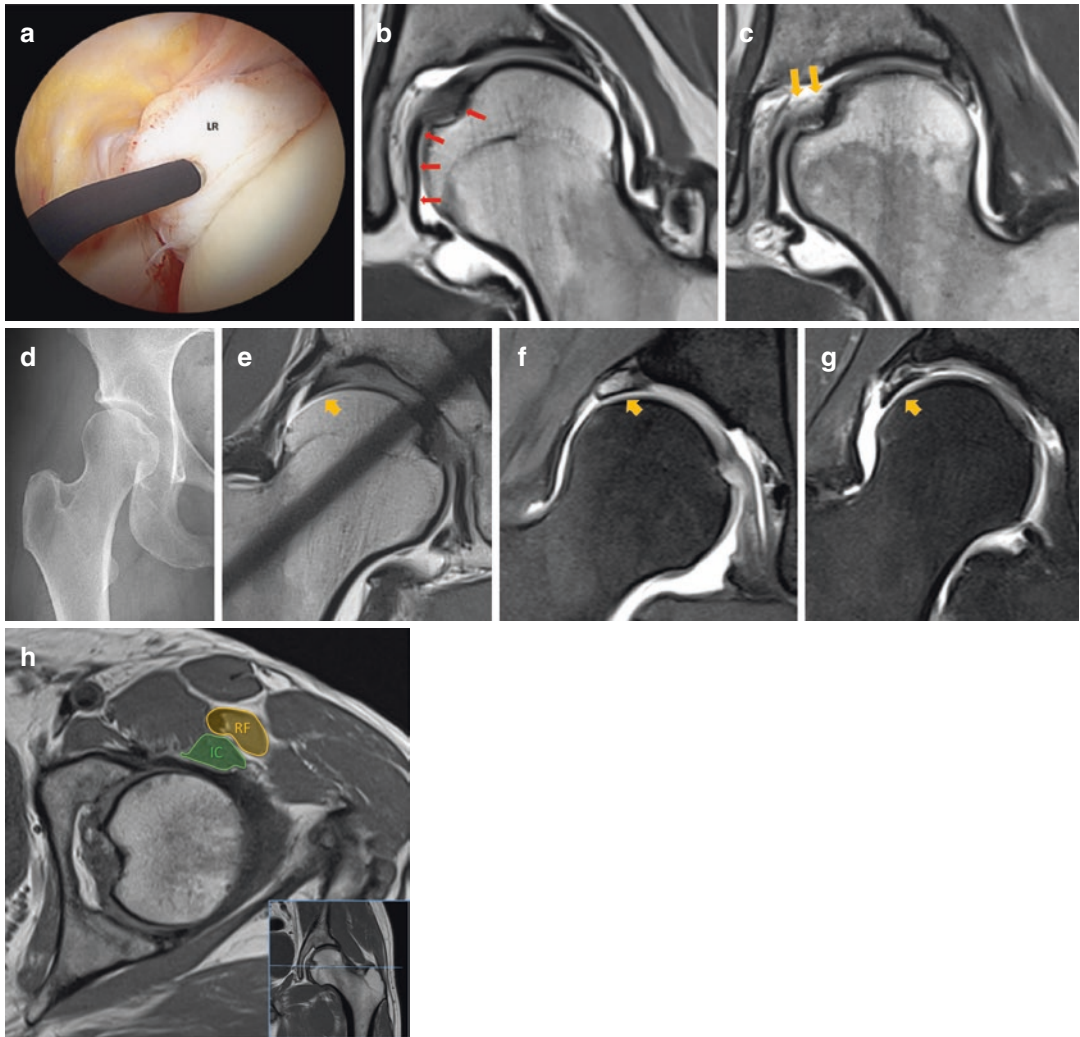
(a–h) (a) Hip arthroscopic and (b, c) coronal MRA proton-density images of *ligamentum teres* (LT). (a) Hypertrophic degenerated ligament (LR). (b) Normal hypointense LT (red arrows). (c) Degeneration and fraying (partial rupture) of the LT at the foveal insertion. Note the shallow acetabulum, highly located fovea, pear-shaped FH and labrum degeneration all characteristic of DDH in a 25-year-old ballet dancer. (d) Right hip AP radiograph on a 29-year-old ballet dancer shows characteristic DDH, with a shallow acetabulum, *coxa valga*, pear-shaped FH, decreased LCEA and increased acetabular inclination.
